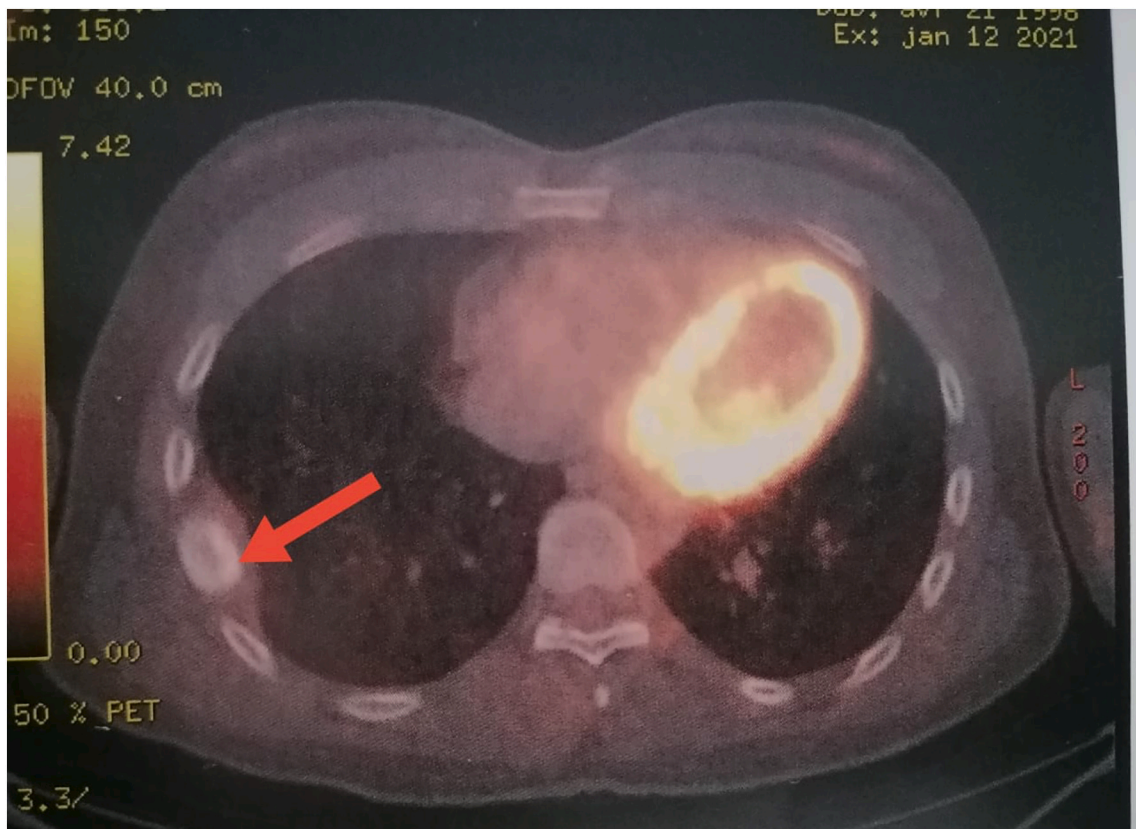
PET CT: A regular non-hypermetsabolic inhomogeneous condensation at the junction of the middle and posterior arcs of the 6th right rib.
